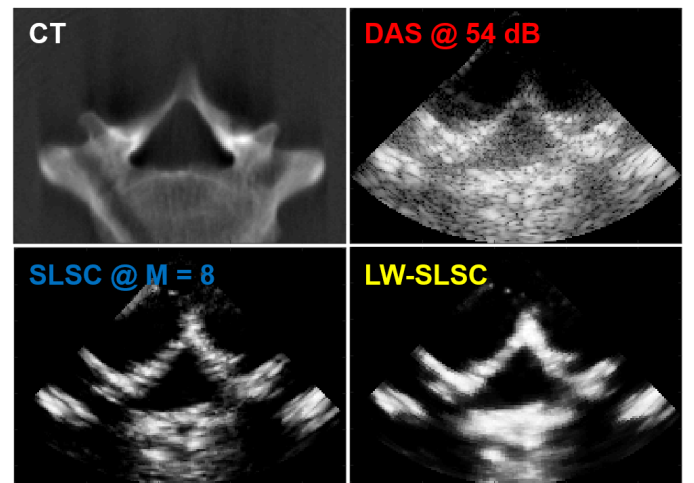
Examples of reconstructed CT, DAS, SLSC and LW-SLSC images (65 mm axial x 90 mm lateral) of the human vertebra (non-registered). Observe that both SLSC and LW-SLSC have similar lateral resolution and the LW-SLSC image has greater CNR.
